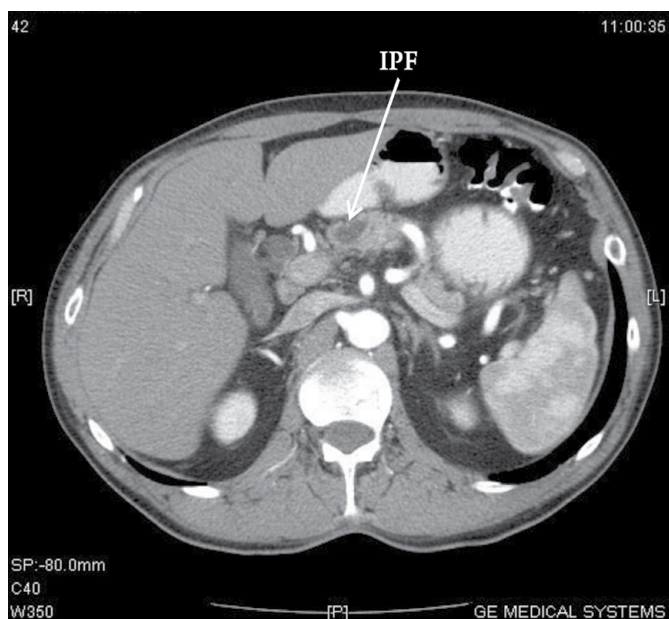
Example of a patient with an internal pancreatic fistula (IPF) in the place of the caput-body junction which is clearly identified at thin-slice helical CT-scan as a regular hypodense zone (arrow) with adjacent parenchymal atrophy.
